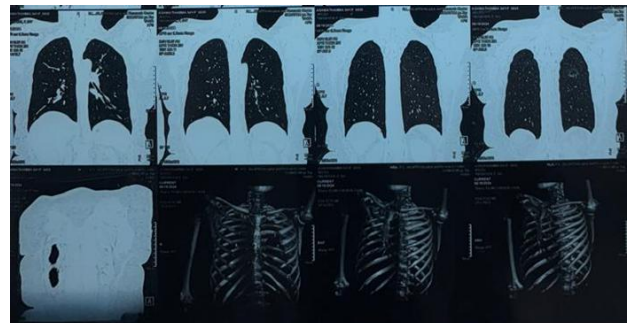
CT thorax showing no involvement of lung or liver.
